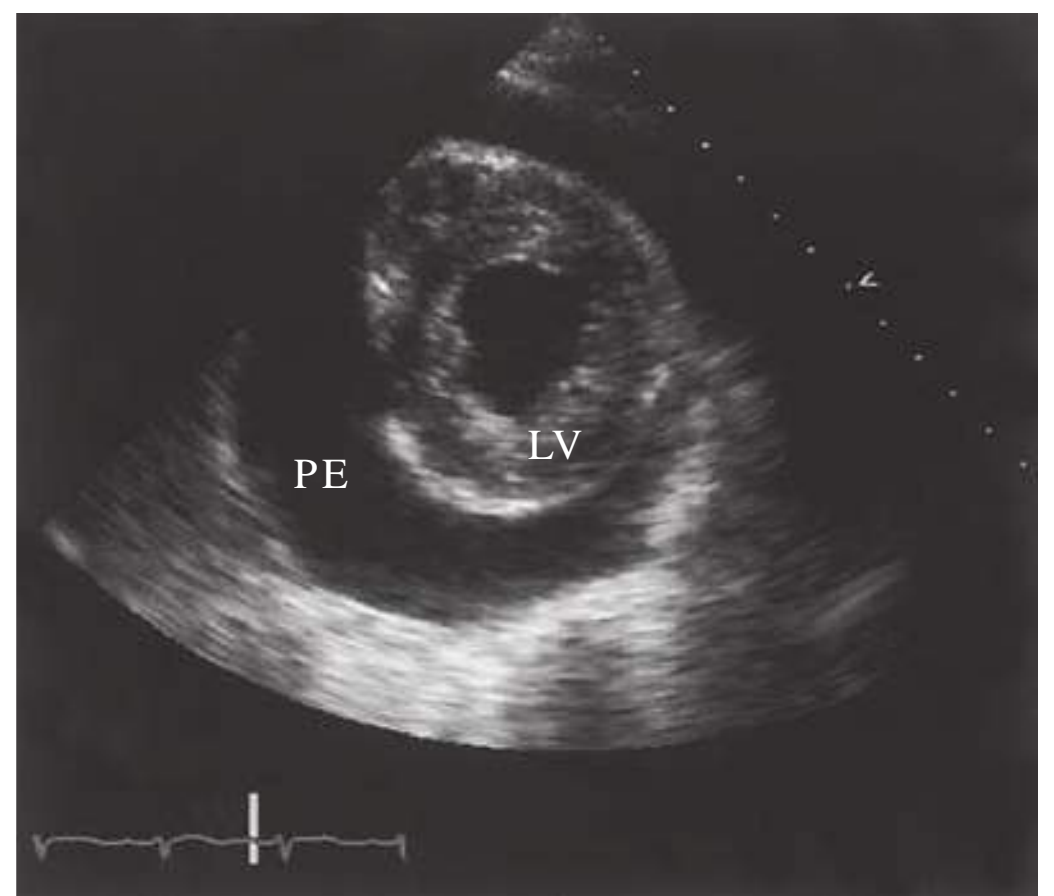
Two-dimensional echocardiogram (parasternal short-axis view) of a pericardial effusion (PE) surrounding the heart. LV, left ventricle.
